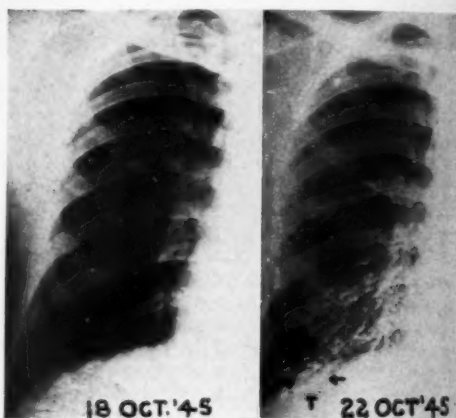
Case 4: Roentgenogram, Oct. 18, 1945; bronchogram, Oct. 22, 1945, showing definite bronchiectasis beneath the right diaphragmatic shadow.
